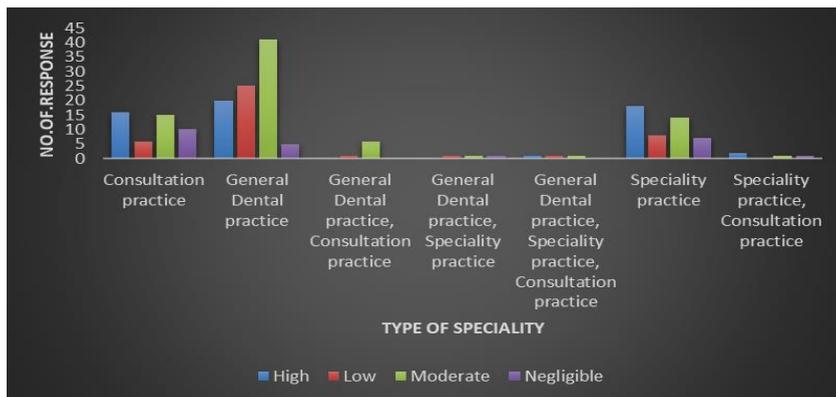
depicts the risks of suggesting CBCT scans for children below 18 years.
